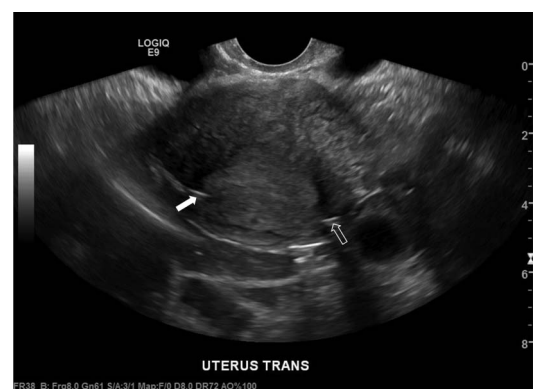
Transvaginal ultrasound revealing an appropriately positioned Essure microinsert (solid arrow) within the right fallopian tube; the microinsert on the left (open arrow) appearing to be in or through the myometrium.
